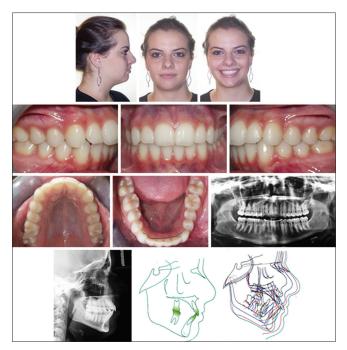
At 14 years 5 months. Posttreatment photographs, panoramic and cephalometric radiographs, cephalometric tracings, and superimpositions. Black: initial; blue: progress; red: final
